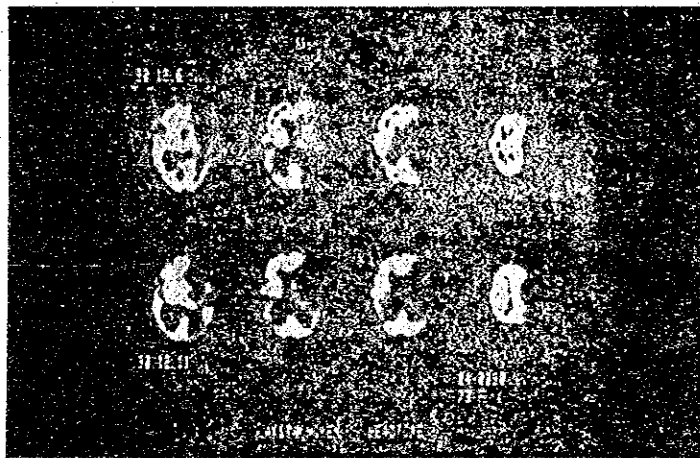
SPECT images using ^{99m}Tc -HM-PAO (before and after embolytic therapy)
